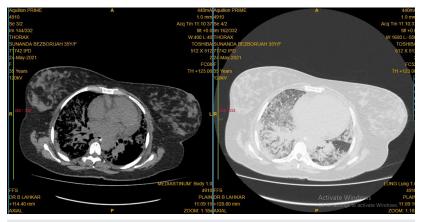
CT Scan Thorax of Case 3 Showing Bilateral Ground Glass Opacities
